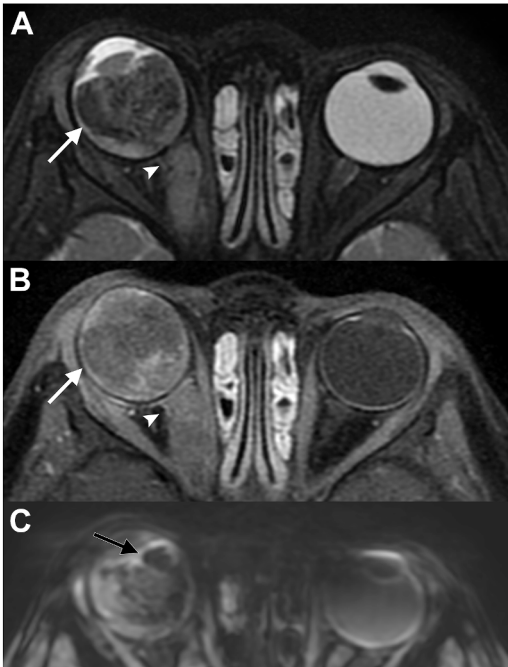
Axial T2-weighted fat-suppressed (A) and fat-suppressed gadolinium-enhanced T1-weighted (B) and T2* (C) MR sequences show a right retinoblastoma with low T2-weighted signal and heterogeneous enhancement (white arrows). Blooming low signal on T2* (black arrow) indicates intralesional calcifications. There is optic nerve invasion (white arrowhead).
